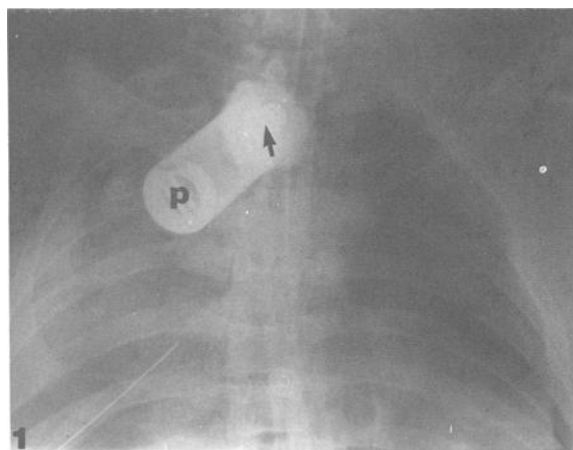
Anterior-posterior chest X-ray demonstrates a very large, radiopaque projectile embedded in the upper thoracic vertebrae. The electrical detonator cap (arrow) as well as the ports (P) on the opposite end of the CAD are visible in the X-ray (AFIP Neg. 85-10578).
